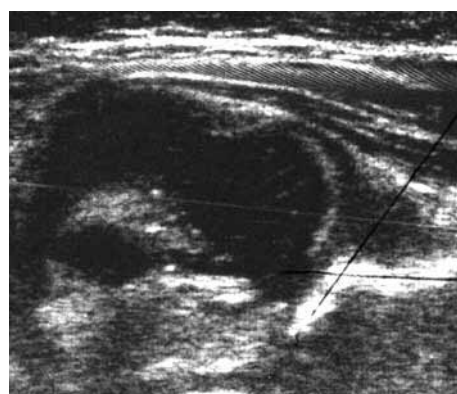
Case 1. Ultrasound scan of the left hip taken at 10 weeks old showing a subluxed left hip and an alpha-angle of 57 degrees.
